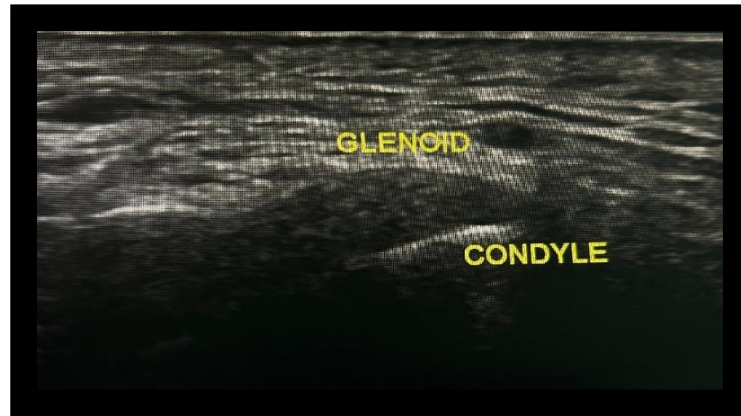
Ultrasonography showing glenoid fossa and condyle
